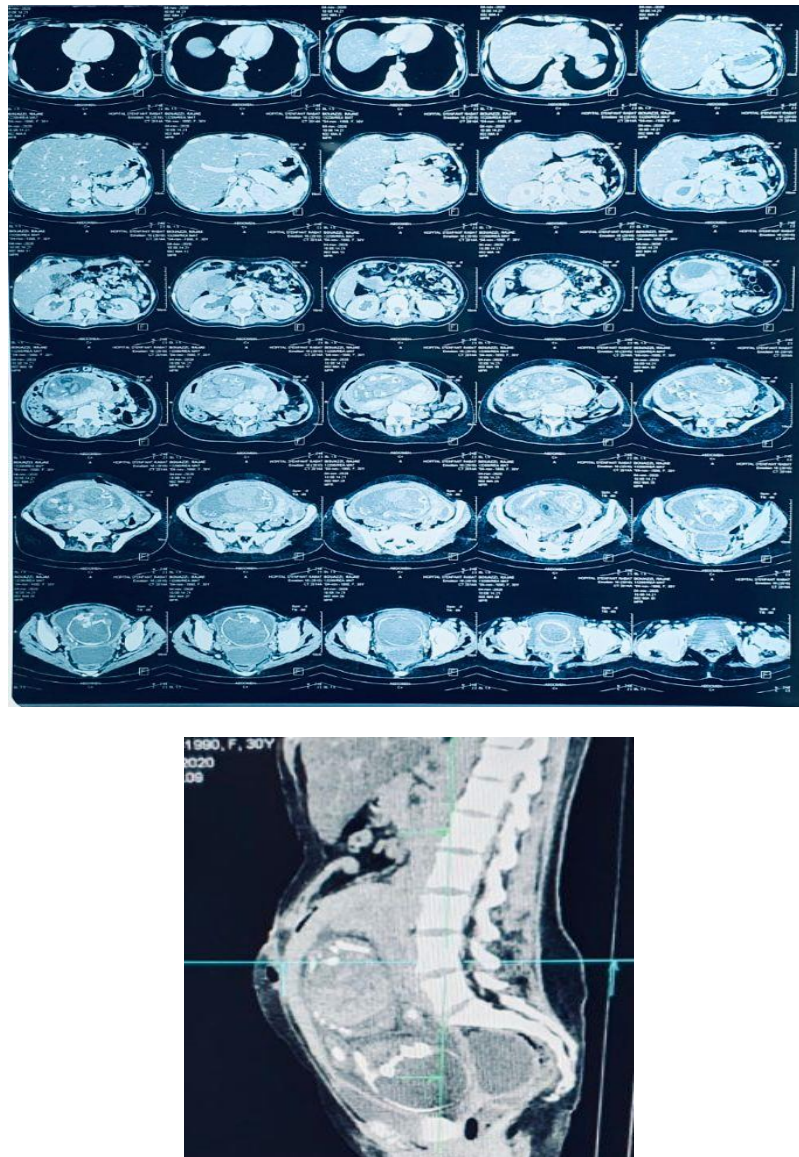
CT imaging showing pericoecal and left pericolic abscessed fluid collections with infiltration of the caeco-appendicular space (sub hepatic location) associated with pneumo-peritoneum, suggesting peritonitis of digestive
